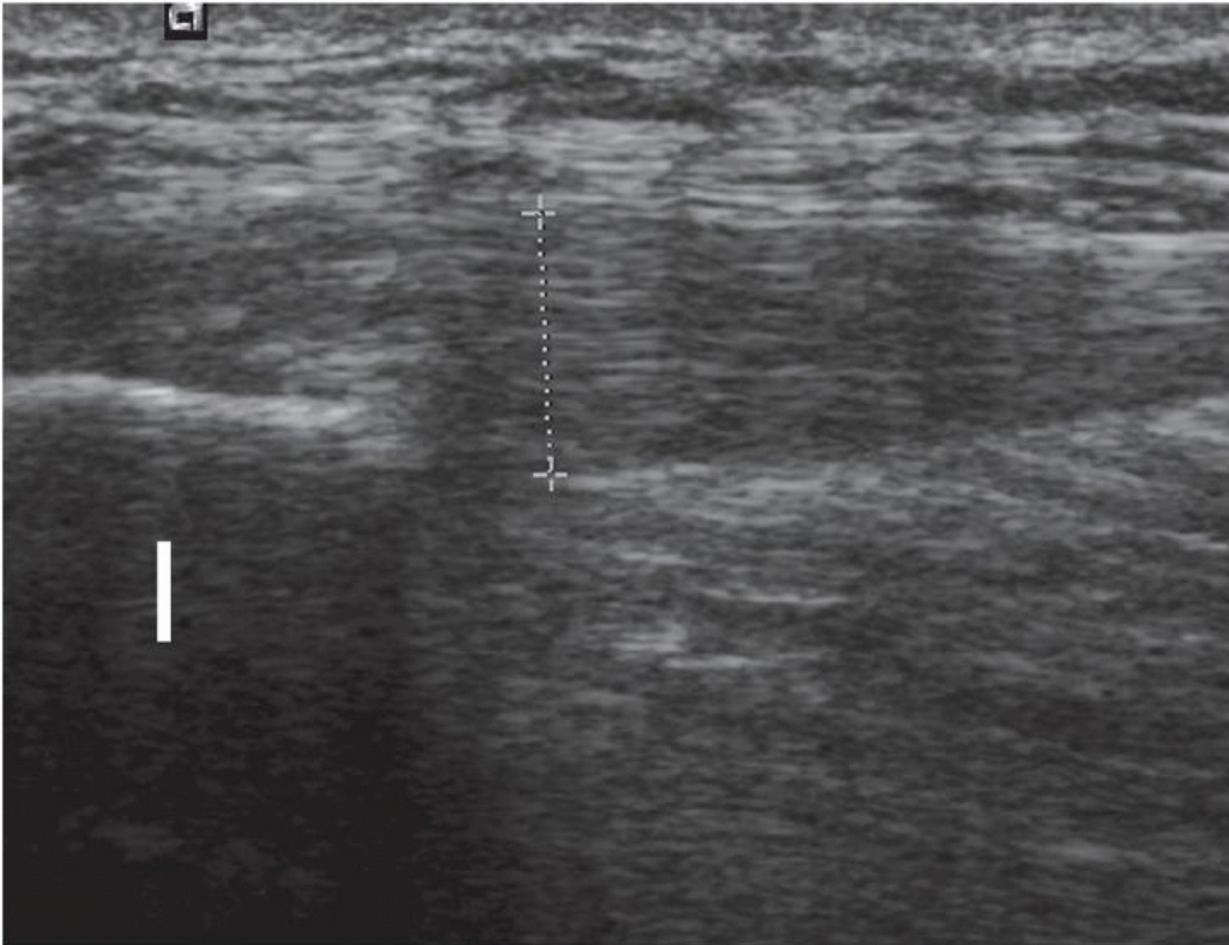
Tendinopathic TFL. Longitudinal sonogram shows thickened hypoechoic TFL (calipers) with maintained fibrillar pattern at the iliac crest origin (I).
